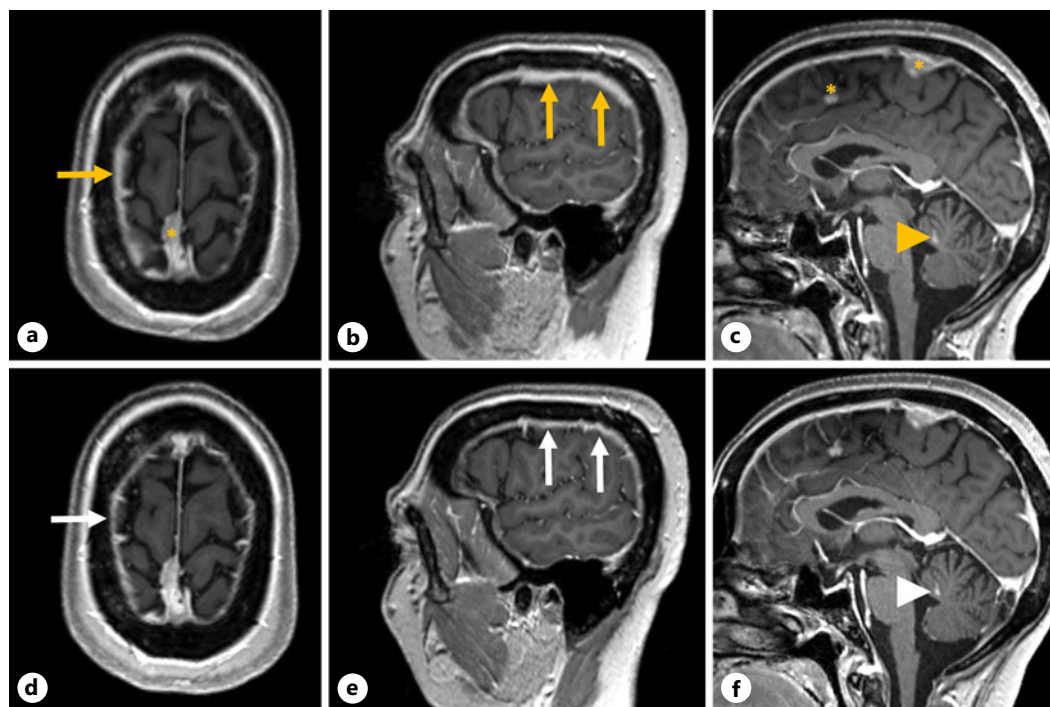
Baseline and follow-up brain MRI baseline brain MRI (top line, a, b) demonstrated diffuse vividly enhancing dural thickening (orange arrows) on axial (a) and sagittal (b) post-contrast gradient-echo 3D T1-weighted images. Two focal nodular lesions along the anterior and posterior falx (c, orange stars) were considered potential dural metastases or meningiomas, and a nodular enhancing lesion in the vermis corresponded to brain metastasis (orange arrowhead). At the 3-month follow-up brain MRI (bottom line), pachymeningeal thickening significantly decreased from 6 to 3 mm (white arrows) in either the axial (d) or sagittal (e) planes. The dural nodules and vermian metastases are stable in size (f, white arrowhead). The response was stable at a 6-month follow-up brain MRI (not shown). MRI, magnetic resonance imaging.
